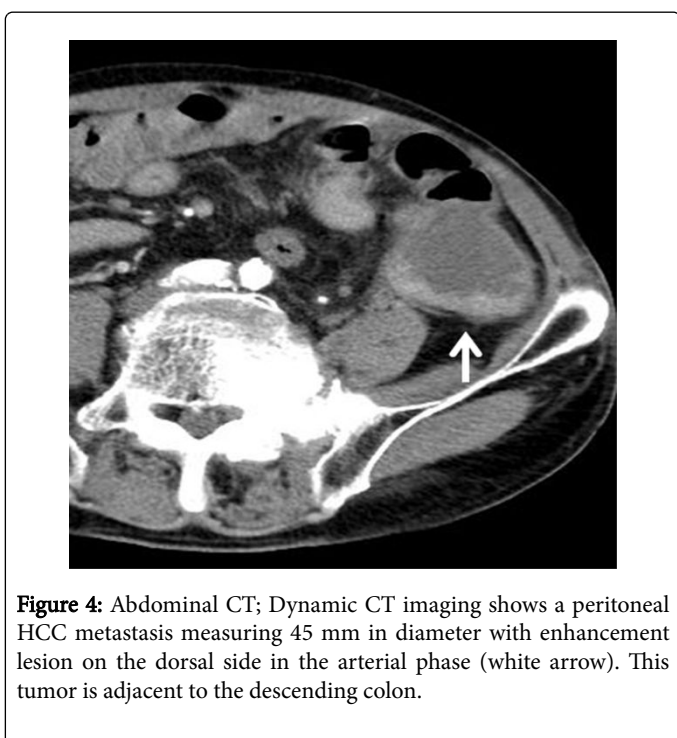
Abdominal CT; Dynamic CT imaging shows a peritoneal HCC metastasis measuring 45 mm in diameter with enhancement lesion on the dorsal side in the arterial phase (white arrow). This tumor is adjacent to the descending colon.
